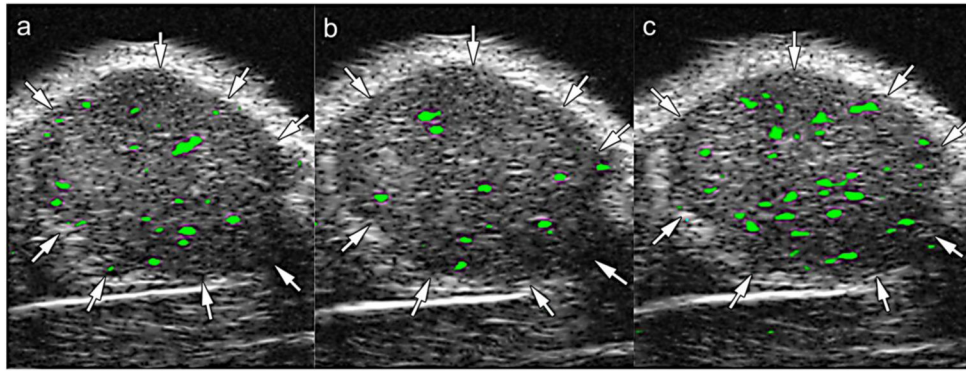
Dual targeting improves the efficacy of contrast-enhanced ultrasound with targeted microbubbles
